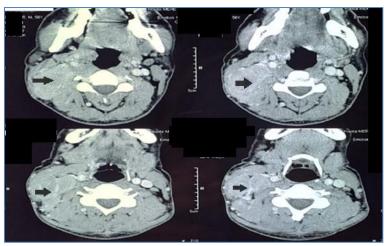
CT scan imaging presenting right magmas lymadenopathies (black arrow) pushing back the vascular axis which remains permeable
